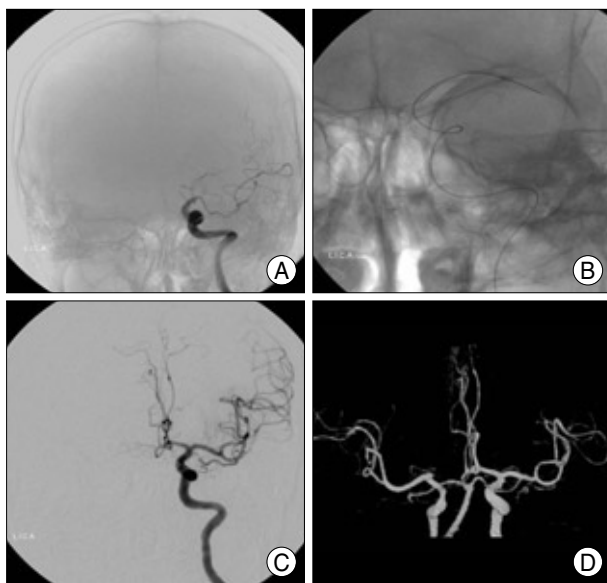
Case of 63-year-old man with acute onset of right hemiparesis. A : After intravenous recombinant tissue plasminogen activator, angiography shows a near-complete occlusion of left distal internal carotid artery (ICA). B : A intra-arterial urokinase with mechanical clot disruption, and followed balloon angioplasty was performed. C : A final angiography shows a successful recanalization of the left distal ICA. D : Computed tomography angiography after 3 months shows a good arterial patency.
